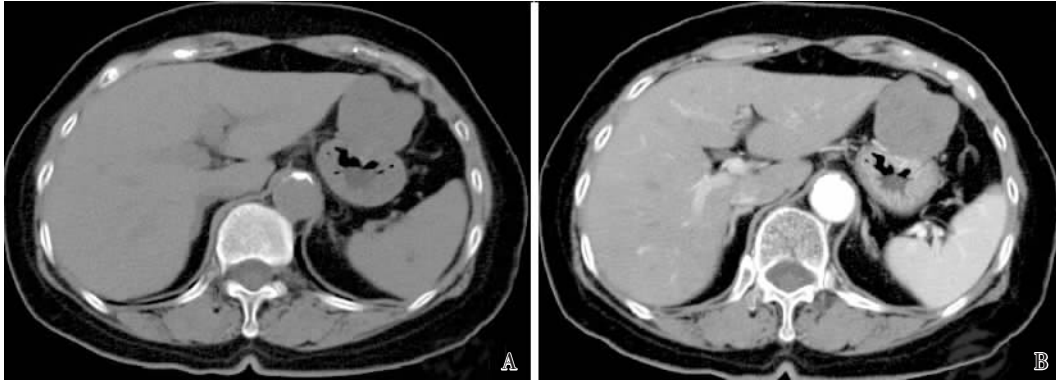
CT features of gastrointestinal stromal tumor (GIST)
